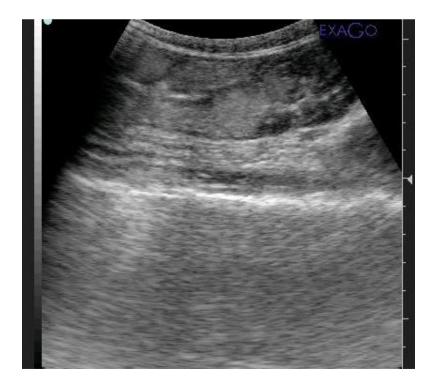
Ultrasound image, using 3.5 MHz curvilinear transducer, showing presence of loops of intestine.
